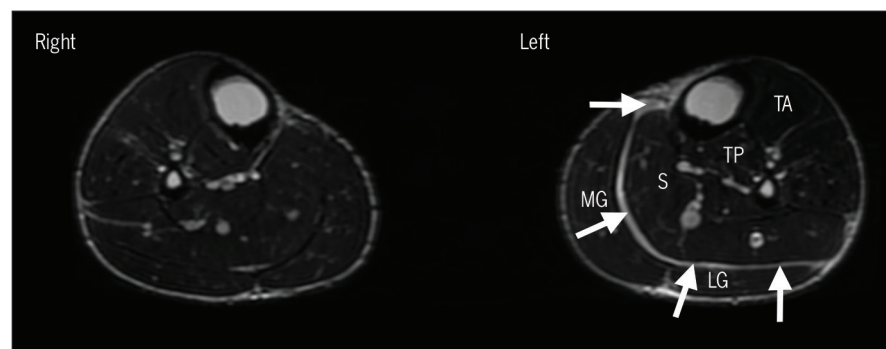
Follow-up (day 8 post injury) T2-weighted axial magnetic resonance imaging (fast recovery, fast spin-echo) image. The white arrows represent diminished edema. Abbreviations: LG, lateral gastrocnemius; MG, medial gastrocnemius; S, soleus; TA, tibialis anterior; TP, tibialis posterior.
